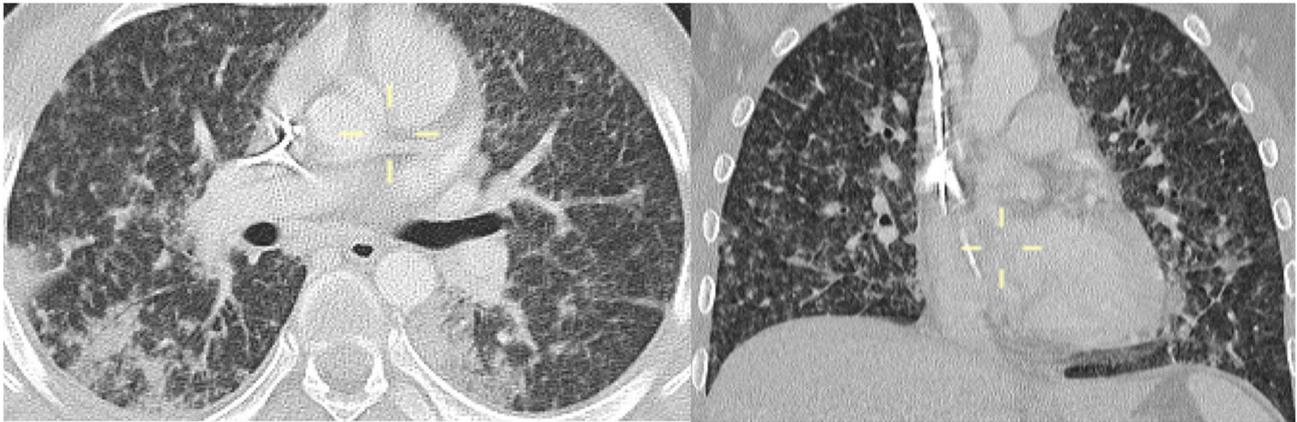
Axial and coronal CT reconstitution (patient 5)—peripheral interstitial thickening with intralobular nodules; subpleural regions are not involved.
